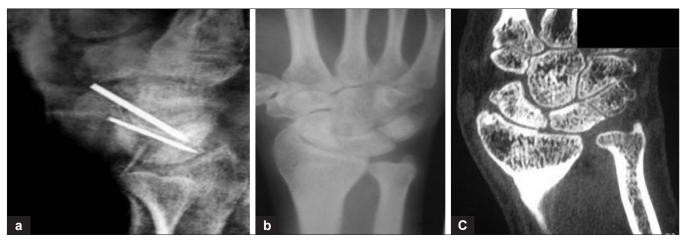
Postoperative x-ray wrist joint showing (a) graft and k-wires in situ with reduction in lateral intrascaphoid angle (b) union after 6 months (c) Union confirmed on CT scan
